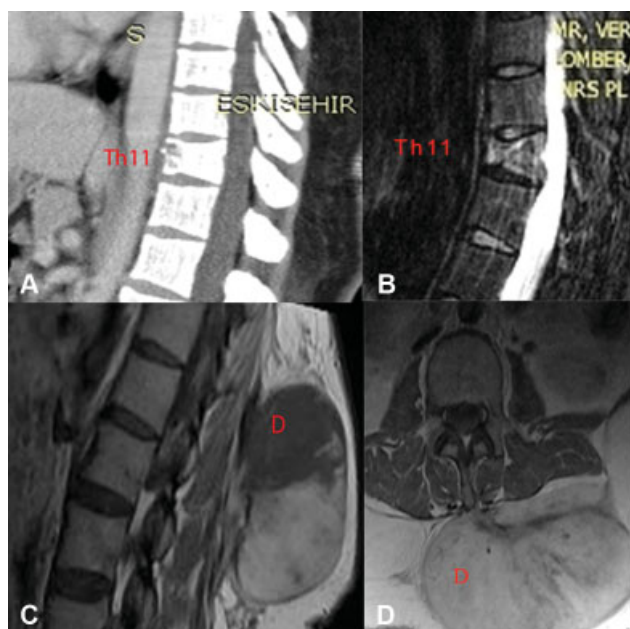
(A) Computed tomography (CT) scan of spine after trauma. T11: compression fracture at the T11 level (B) Magnetic resonance imaging scan of T11 demonstrates the fracture-related edema. (C) Sagittal scan of vertebral body after 6 months. A desmoid tumor (10 × 6 × 7 cm) can be observed at T11 and L2 levels. (D) Axillary scan of vertebral body and desmoid tumor. Abbreviations: T: thoracic vertebra, D: desmoid tumor.
